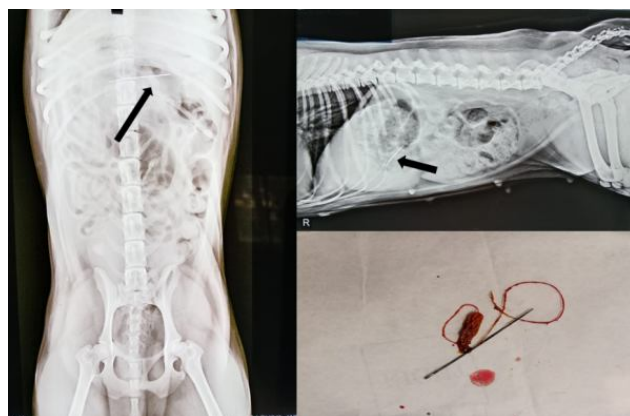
The radiograph revealed presence of linear, sharp ended metallic foreign body lodged at a part of transeverse colon. The stomach showed presence of gases, without any foreign materials
